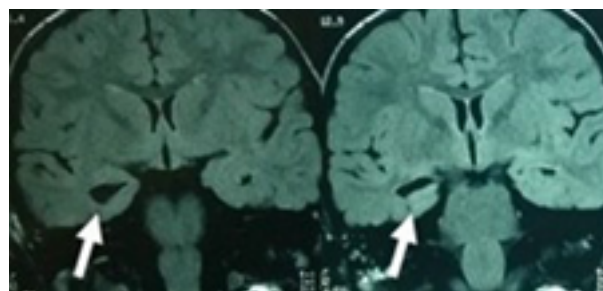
MRI of brain coronal views showing right-sided (arrow indicated) MTS (mesial temporal sclerosis). Source: Figure by authors.
